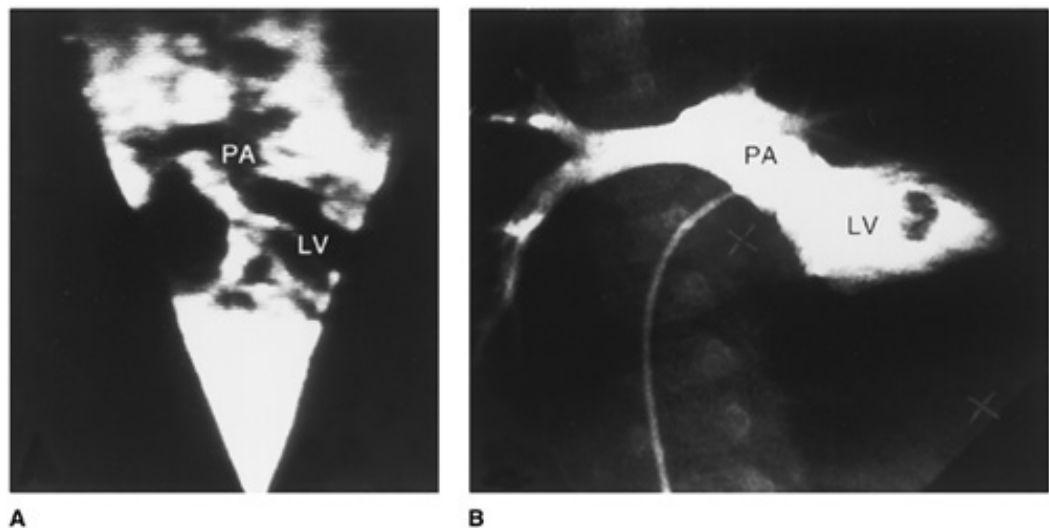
A.* Two-dimensional echocardiogram. The left ventricle leads to a bifurcating great vessel (pulmonary artery, PA), confirming transposition. *B.* Anterolateral projection of an angiogram in the smooth-walled left ventricle (LV). The dye is ejected into the pulmonary artery.
